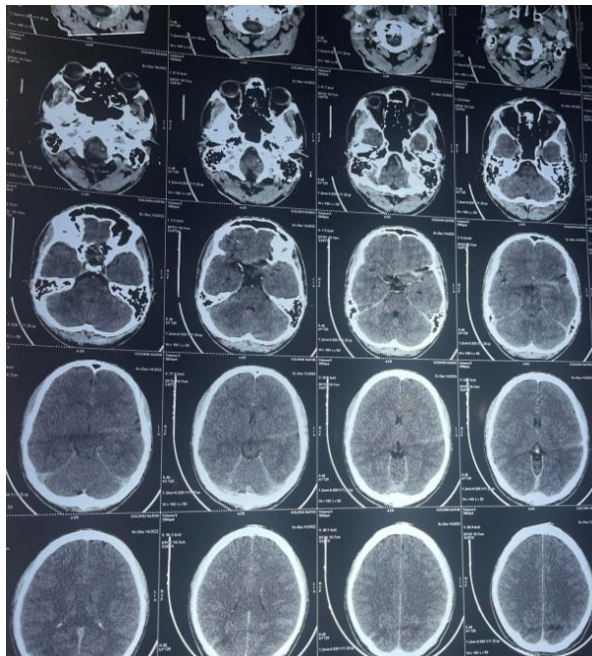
A cerebral CT showed a slight cerebral edema with exaggerated hyper density of the cerebral tent.
